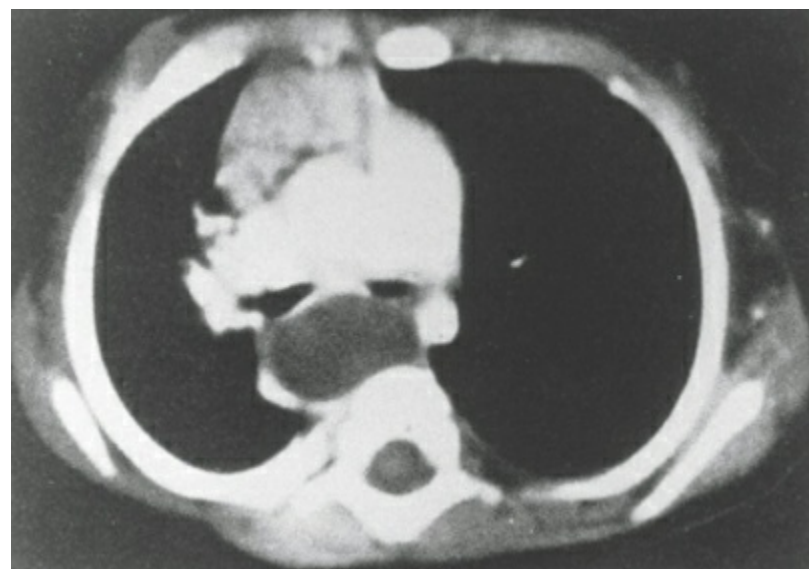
Computed tomography scan reveals a bronchogenic cyst located in the subcranial area with compression of the left mainstem bronchus with hyperinflation of the left lung and a mediastinal shift to the right. (Reproduced with permission from Shields TW. Primary lesions of the mediastinum and their investigation and treatment. In: Shields TW, ed. *General Thoracic Surgery*. Baltimore, MD: Williams & Wilkins; 1994:1764–1769.)
